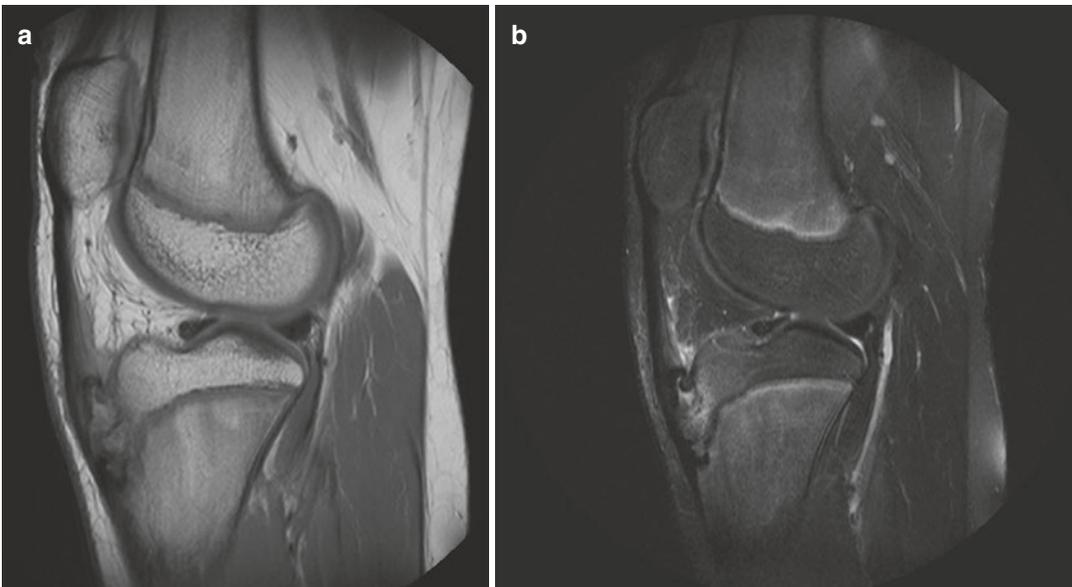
(a and b) Sagittal T1 proton density weighted (a) and T2 fat-saturated MRI sequences demonstrating Osgood–Schlatter’s disease
